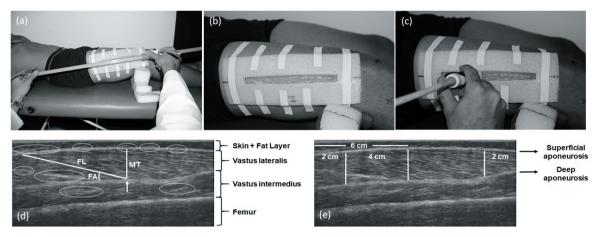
Determining the position of the guiding rail for transducer positioning (a, b, c); extended-field-of-view (EFOV) ultrasound images of the vastus lateralis muscle with internal anatomical landmarks identified (d) and with predetermined distances (e).
